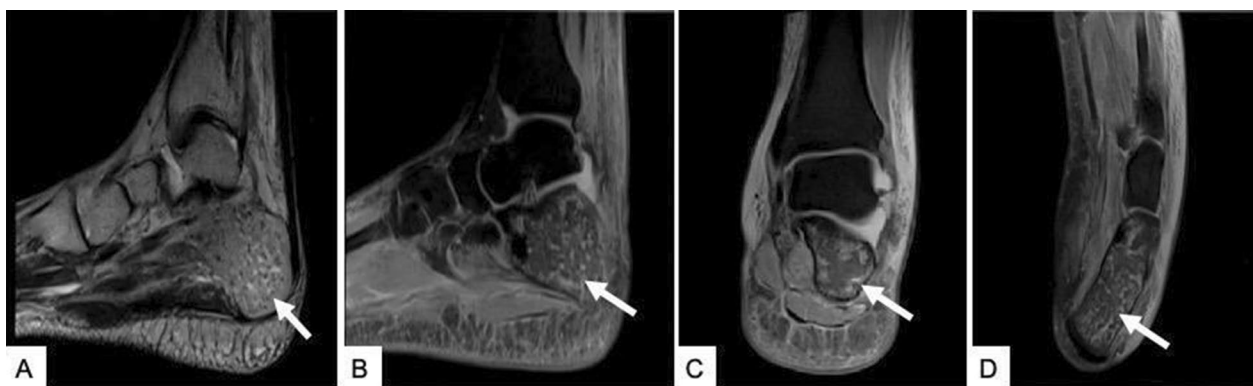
MRI of left ankle—T2W sagittal A and proton density (PD) Fat-Sat sagittal B, coronal C and axial images D showing an ill-defined hyperintense lesion in the calcaneum (arrow) with minimal effusion in the talocalcaneal joint—features suggestive of calcaneal osteomyelitis
